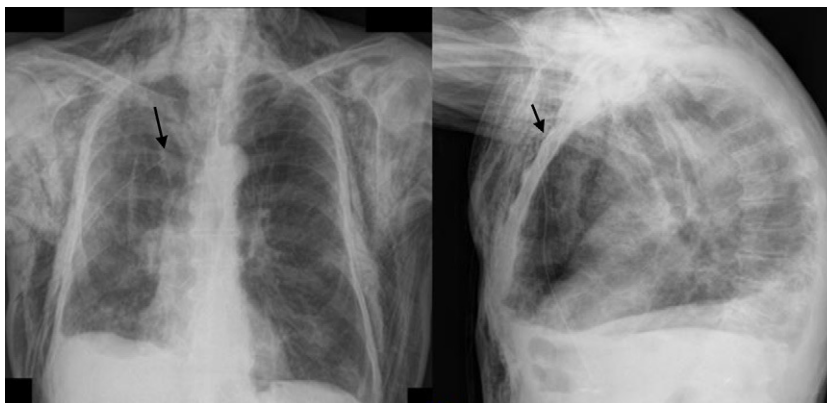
Posteroanterior and lateral chest radiography showing massive accumulation of air in the subcutaneous tissue. The proximal end of the subcutaneous drain can be observed in the third right intercostal space (arrows).
